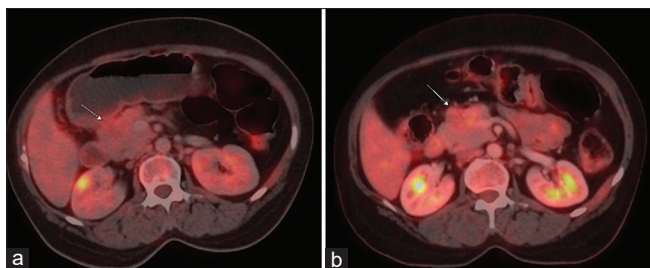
The ^{18}F -fluorodeoxyglucose positron emission tomography-computed tomography scan at baseline (a) and postchemotherapy (b) shows ill-defined heterogeneously enhancing lesion involving the head of pancreas (arrows). There is mild increase in the size of lesion and metabolic activity on follow-up scan suggestive of early disease progression
